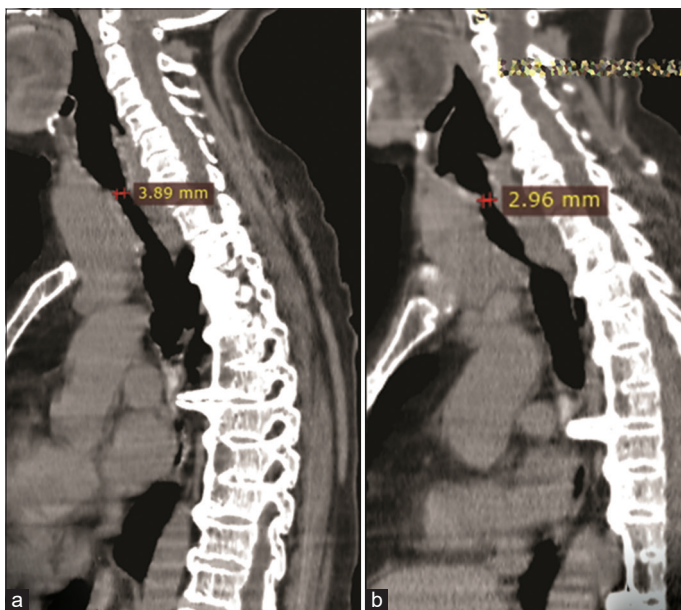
Computed tomography sagittal view of the mediastinal window showing tracheal luminal narrowing at the seventh cervical vertebrae from 3.8 mm (a) to 2.9 mm (b)
